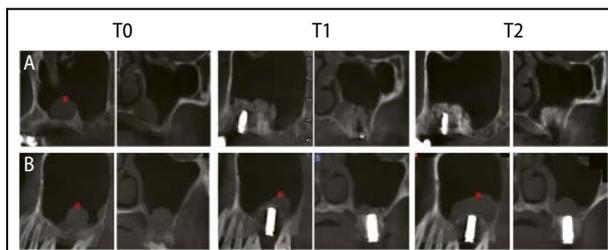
Representative CBCT images showing well-defined, hyperdense, unilocular, dome-shaped mass in the sinuses (*). Case A: The pseudocyst was removed, and no evidence of a recurrent cyst was observed after 6 months. Case B: The pseudocyst was much larger 6 months postoperatively.
